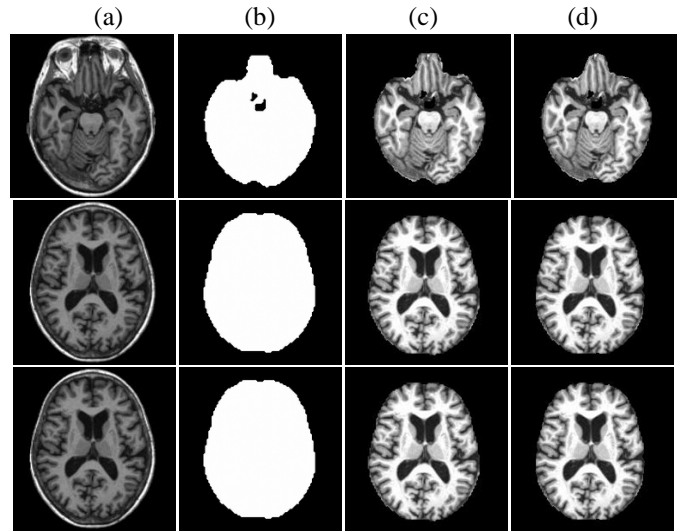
Skull stripped normal brain MR images: a) Input brain MRI, b) Brain mask, c) Skull stripped MR image by proposed method and d) Skull stripped by BET
